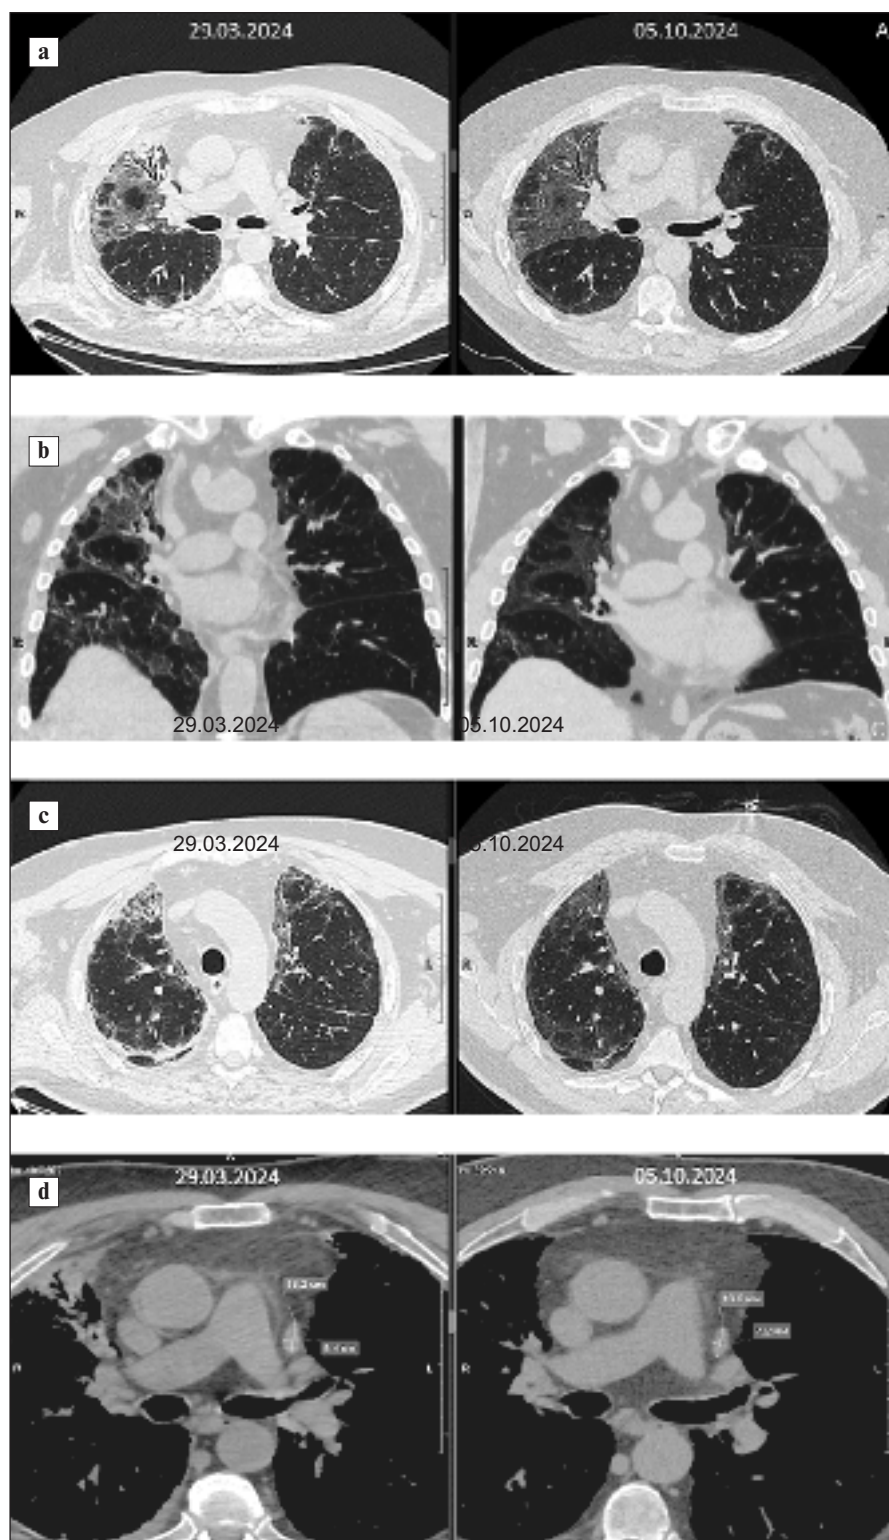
Chest CT of patient N. over time (a–d) after selective plasmosorption of DNA and NETs followed by RTX administration
